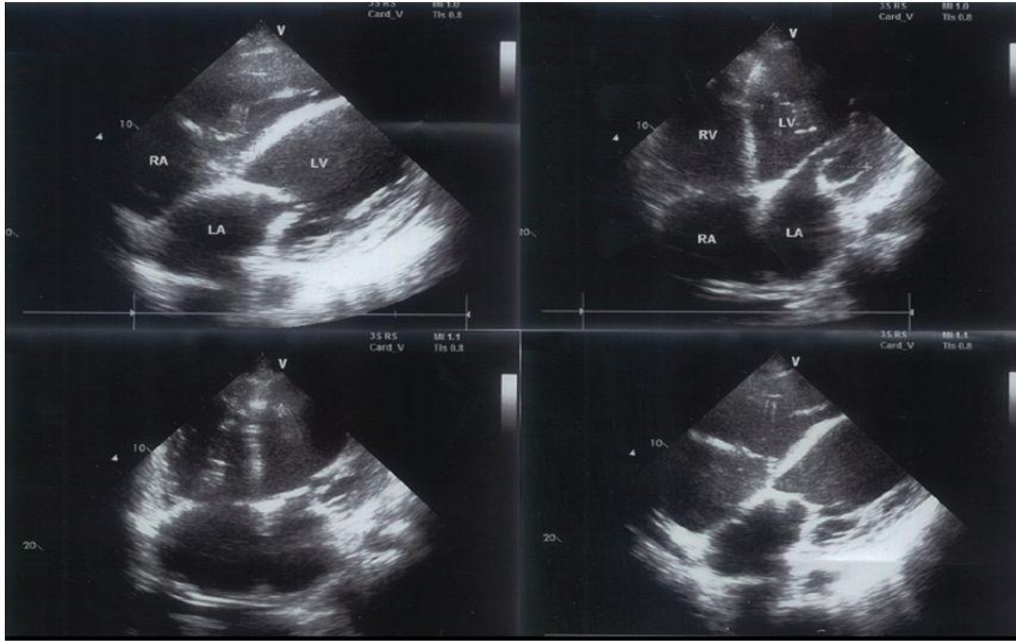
Echocardiographic findings of the patient*
